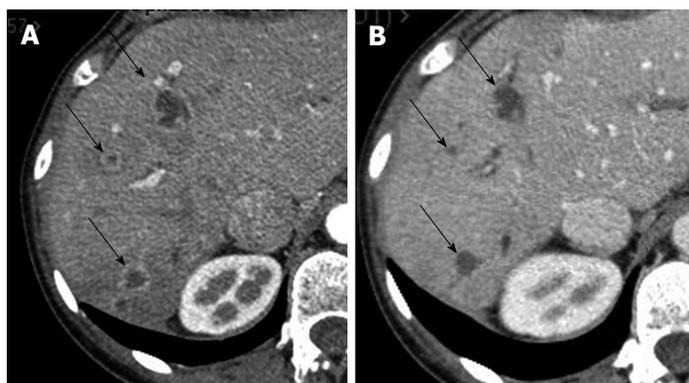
Computed tomography scans (A) prior to and (B) 4 mo after initiating sunitinib treatment, demonstrating density variation of three target lesions (arrows) in the liver. Baseline computed tomography (CT) shows heterogeneous lesions with contrast-enhanced peripheral ring, while post-treatment CT shows disappearance of the hypervascular aspect of the three lesions.
